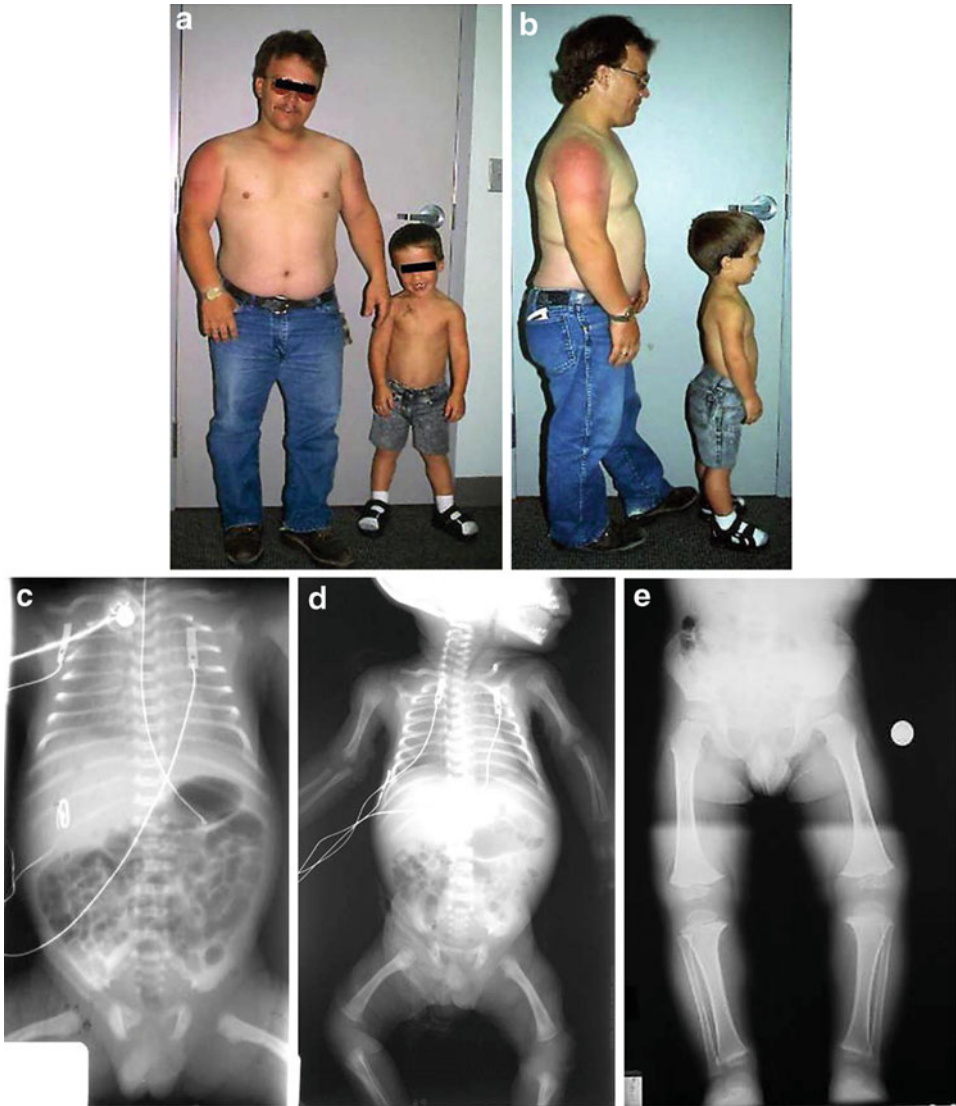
(a–e) Father and son showing typical features of hypochondroplasia. The son's radiographs at birth, 17 days, and 2 years, and 6 months showing unchanged lumbar interpedicular distance, mild shortening of long bones, and short, squared ilia
